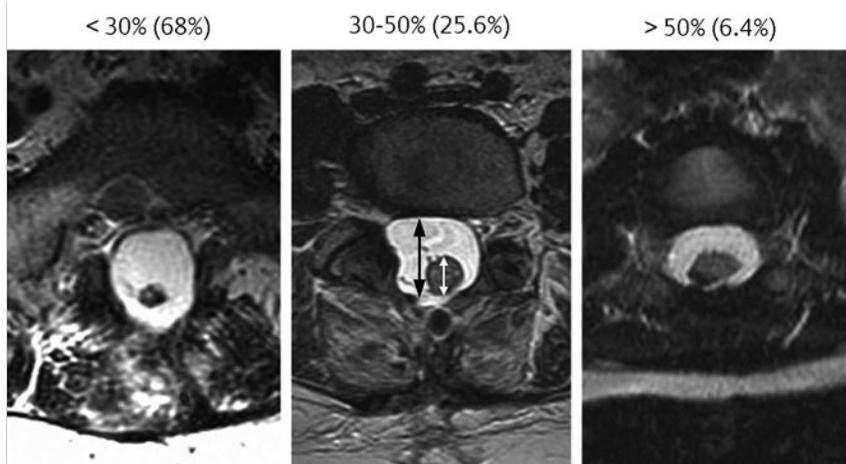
Cord-sac ratios on the postoperative axial magnetic resonance images after total or near-total resection of lipoma. This ratio is obtained by dividing the sagittal diameter of the most bulbous portion of the post-neurulated neural placode by the sagittal diameter of the dural sac. In our series, 68% of the patients had very loose sacs (cord-sac ratios <30%), 25.6% had intermediate ratios (30 to 50%), and 6.4% had high ratios (>50%), with the least commodious cord-sac relationship. The cord-sac ratio estimates the degree of freedom of motion of the post-neurulated spinal cord within its container sac.
